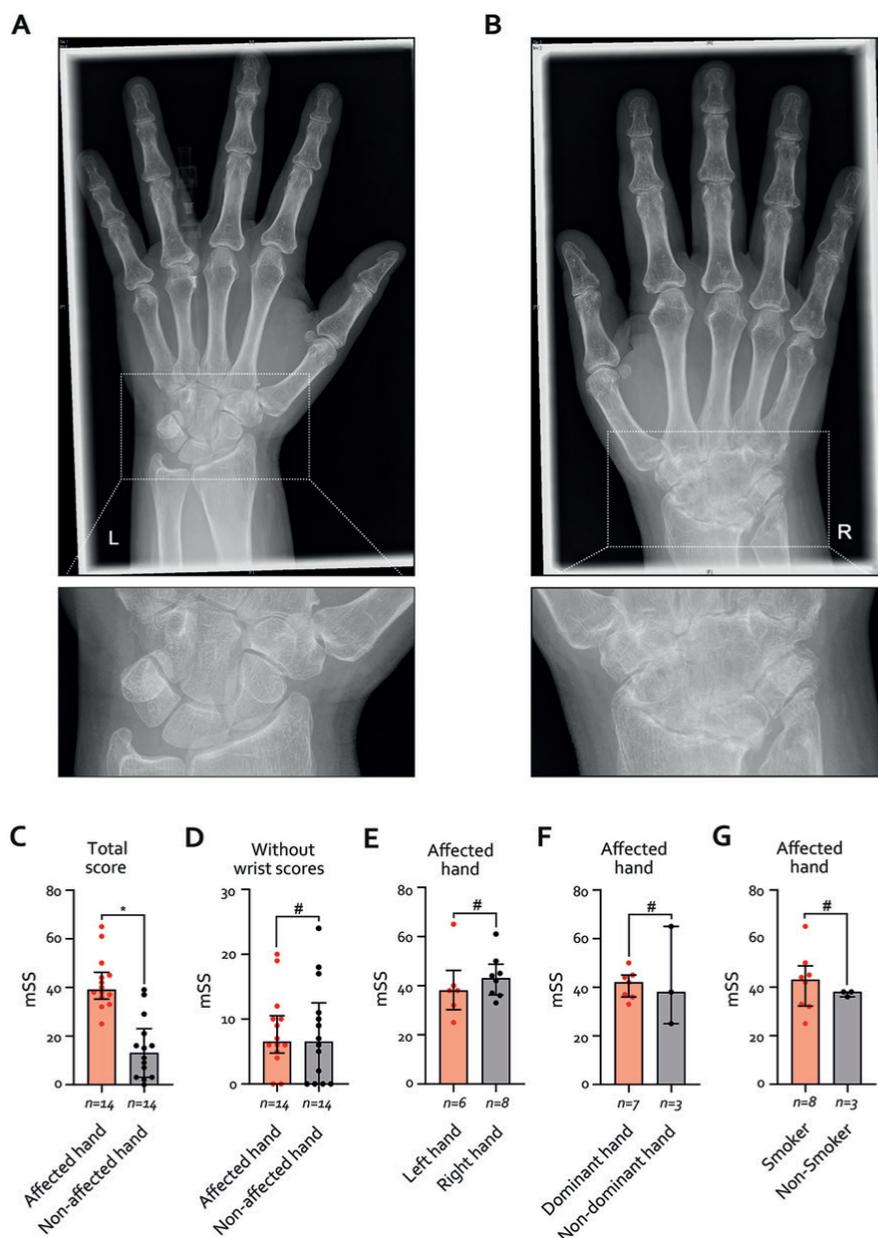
Radiographic presentation of destructive unilateral wrist arthritis and scoring according to the modified Sharp/van der Heijde method.
